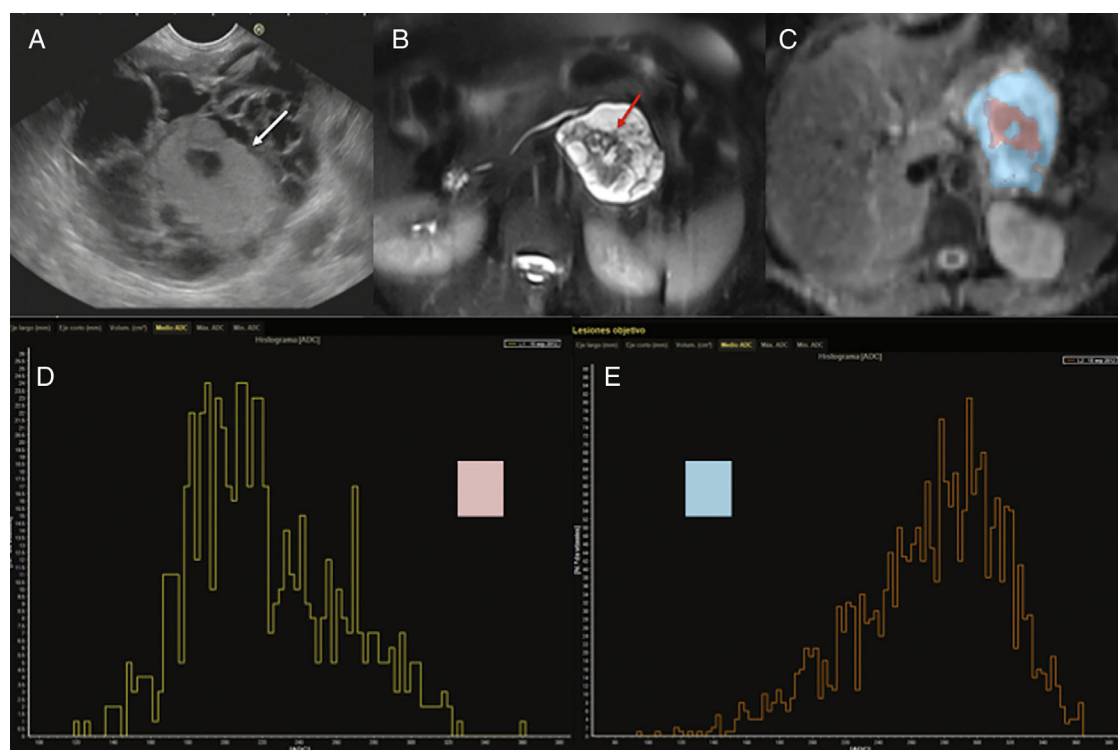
45-year-old female with cystic tumor in the pancreatic tail. Endoscopic ultrasonography (EUS) imaging (A), T2-weighted MRI with fat saturation (B), ADC map with color segmentation of peripheral (blue) and central (pink) portions (C) and histograms corresponding to the ADC values of such portions of the mass (D and E). Both the endoscopic image and the T2-weighted MRI with fat saturation show one cystic mass with a solid central component (white arrows in the EUS image and red arrows in the T2-weighted MRI). The analysis of the ADC map shows the peripheral cystic portion (segmented in blue) with high ADC values in the histogram (E) and an average ADC value of 2.7, while the solid central portion (segmented in pink) shows lower values on the ADC map (D) with an average ADC of 2.1. After the surgery, the anatomopathological diagnosis was mucinous cystadenocarcinoma.
